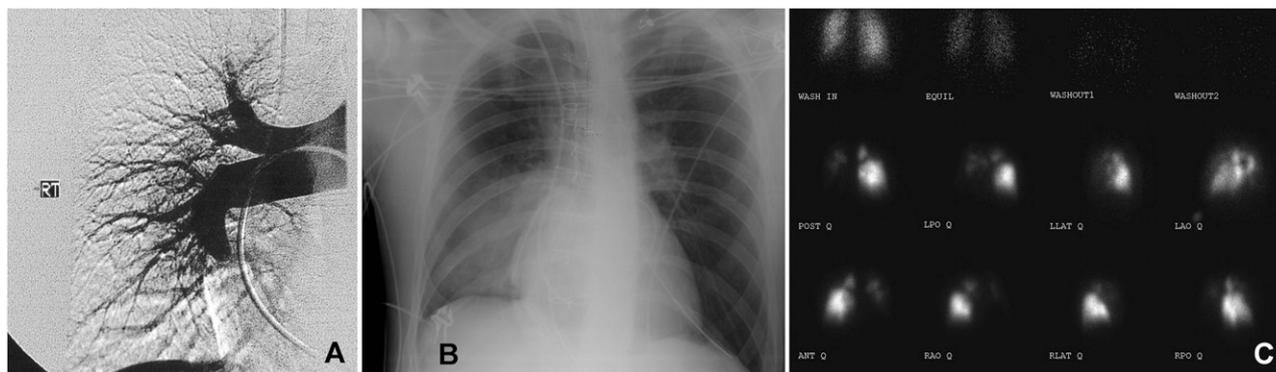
(A) Right-sided pulmonary angiogram demonstrating “pouch” defect in the right lower lobe pulmonary artery. (B) Immediate postoperative chest radiograph demonstrating right lower lobe air space opacity consistent with reperfusion lung injury. (C) Postoperative perfusion scan demonstrating marked redistribution of pulmonary blood flow (pulmonary artery “steal”) into endarterectomized region of lung.
